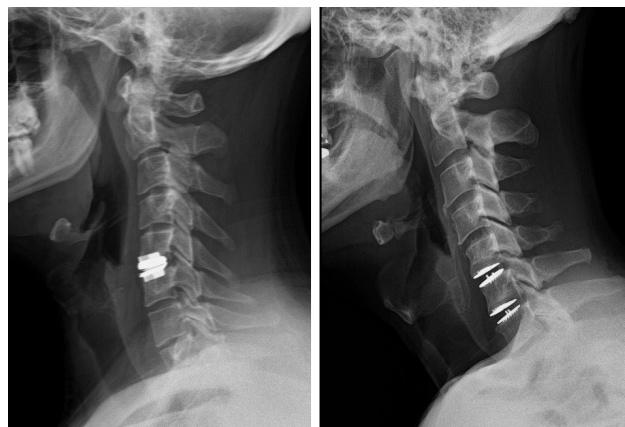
Left x-ray shows a single-level C5-C6 ProDisc device. Right x-ray shows two-level C5-C6-C7 Mobi-C arthroplasty.
